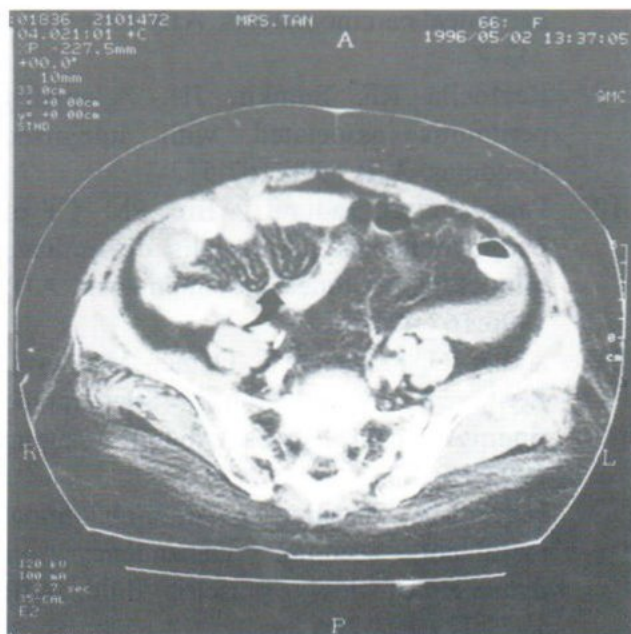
Contrast-enhanced CT scan demonstrates thickened mesenteric leaves (arrow).
